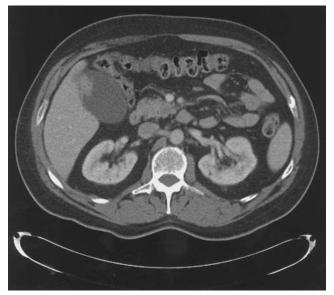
CT of mass in gallbladder later shown to be gallbladder cancer.
